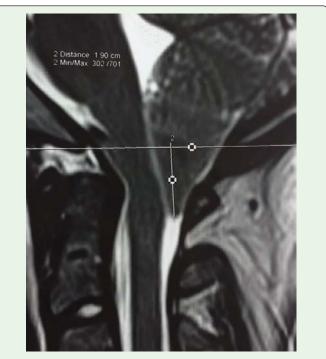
Sagittal T2-weighted MRI scan of the occipitocervical junction and cervical spine. It reveals a compressed, slender, peg-like herniated cerebellar tonsil of 1.90 cm, closely applied to the dorsal surface of the cervical cord.
